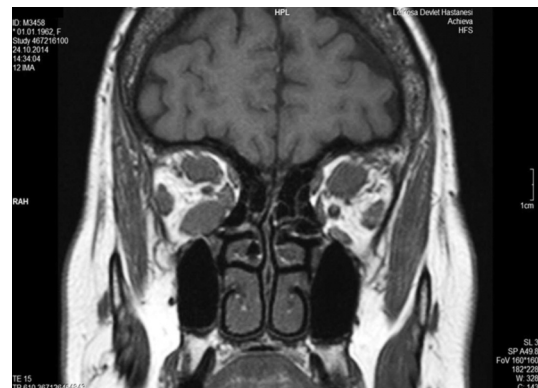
Orbita MRI; coronal plane. Diffuse thickening of bilateral rectus muscles.
